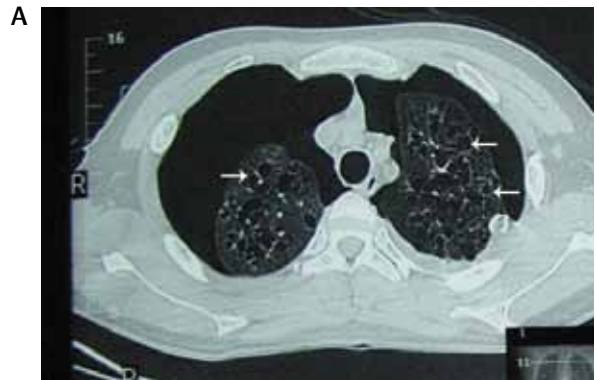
High-resolution computed tomography chest scan showing bilateral pneumothoraces with numerous, well-defined, thin-walled cysts evenly distributed throughout both lung fields; a moderate-sized pleural effusion is also seen on the left side (white arrow)
